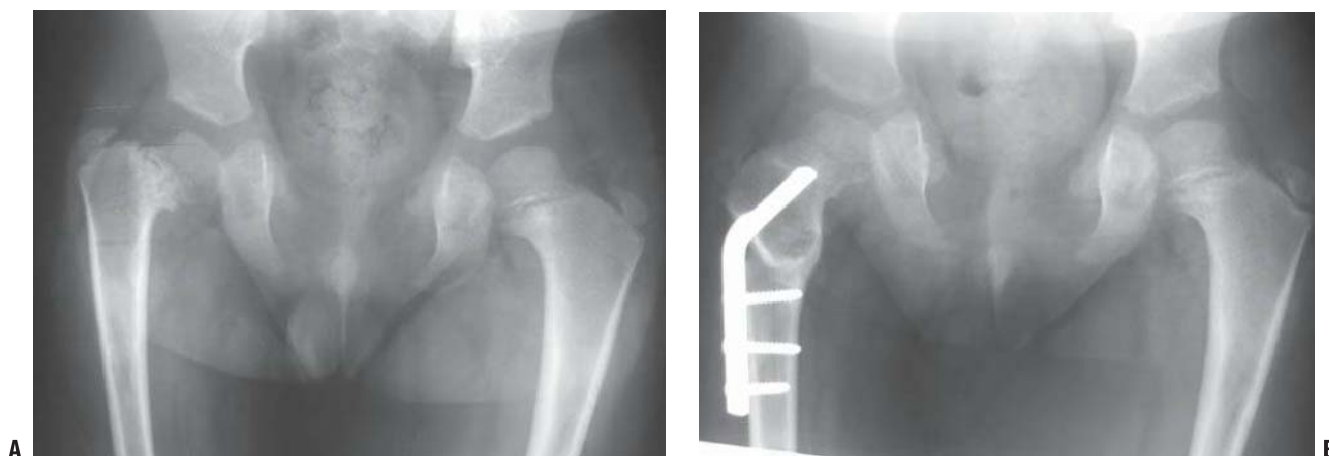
In cleidocranial dysplasia, the pelvis is narrow, the symphysis pubis is widened, the ischiopubic synchondrosis is unossified, and there may be coxa vara. Preoperative (A) and postoperative (B) radiographs.
